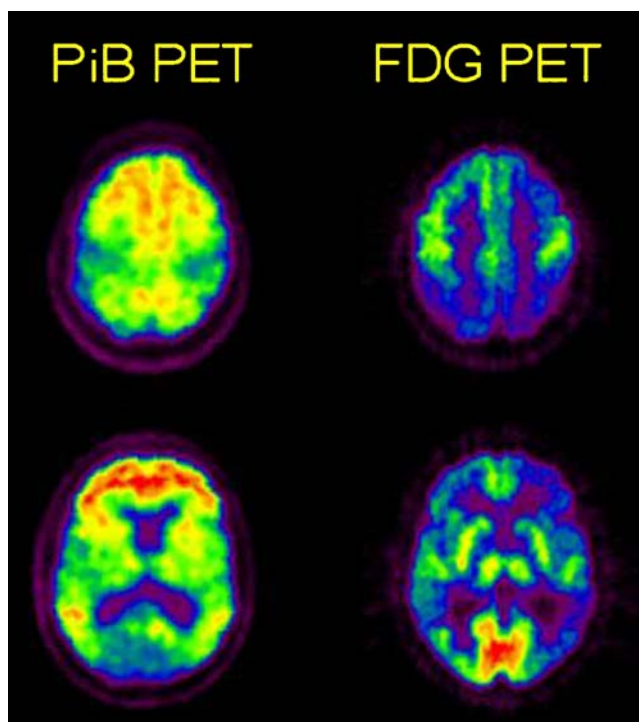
Typical PiB (left panel) and FDG (right panel) PET images in a 82 year-old Alzheimer's disease patient. PiB PET images show radiotracer retention in frontal, temporal and cingulate cortices as well as in the caudate nuclei. FDG PET images show an *inverted* pattern, with areas of glucose hypometabolism matching the areas of high PiB binding
